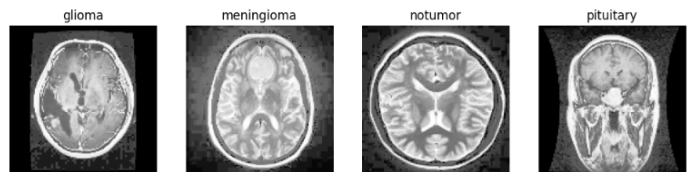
Examples of the labelled MRI brain scan dataset.
